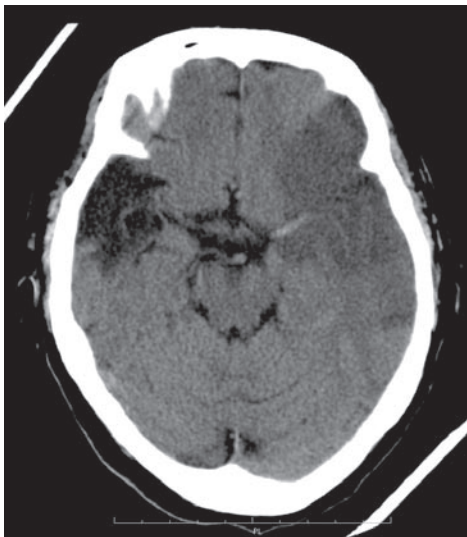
Non-contrast axial CT brain.
